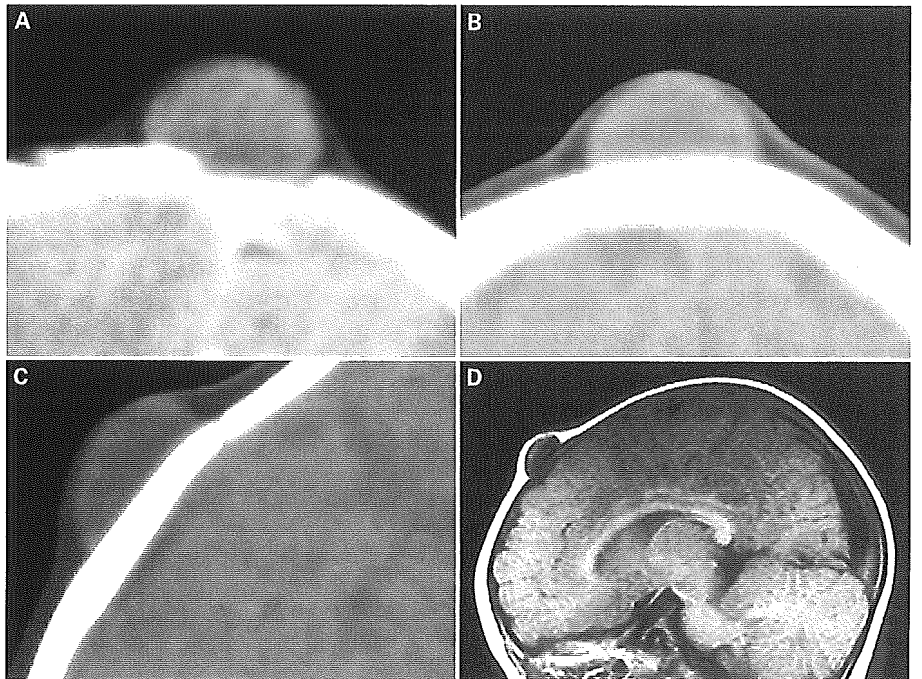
Case 3 at age 9 months. Coronal CT image showing a mass lesion located on the anterior fontanelle (A). CT 3 months later showing that the anterior fontanelle closed and the tumor relocated to the frontal bone (B, C). T₁-weighted image demonstrating a hypointense lesion unconnected to the subarachnoid space or brain parenchyma (D).
